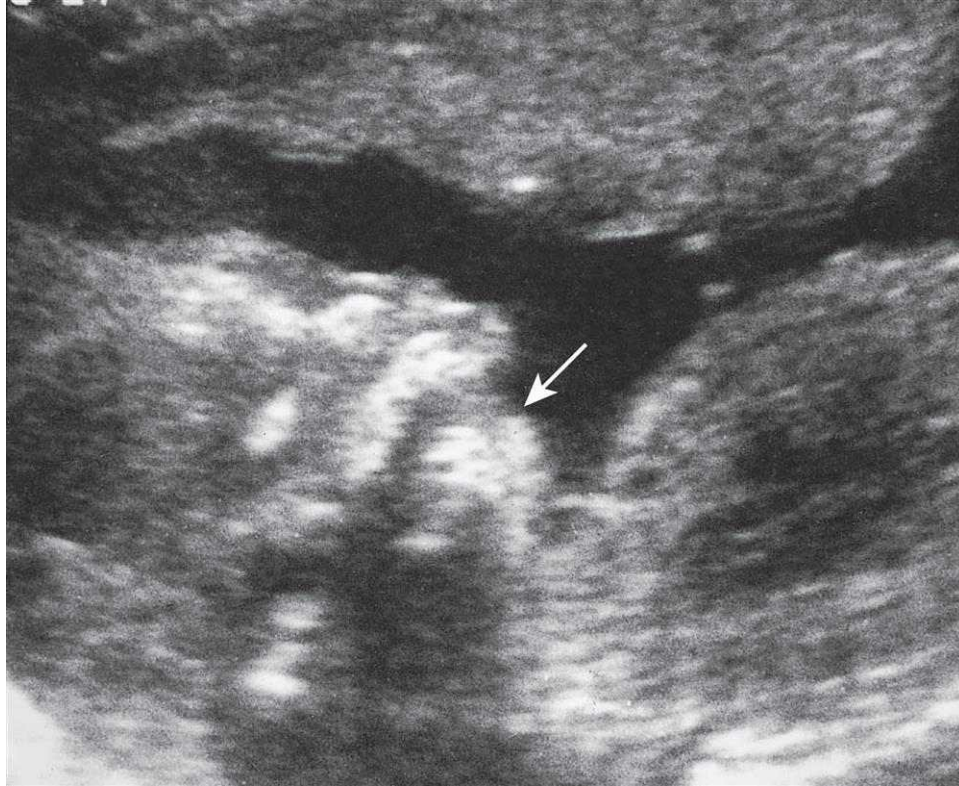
Longitudinal sagittal ultrasonographic image of the head and upper chest of a fetus showing micrognathia (small jaw) (arrow).
